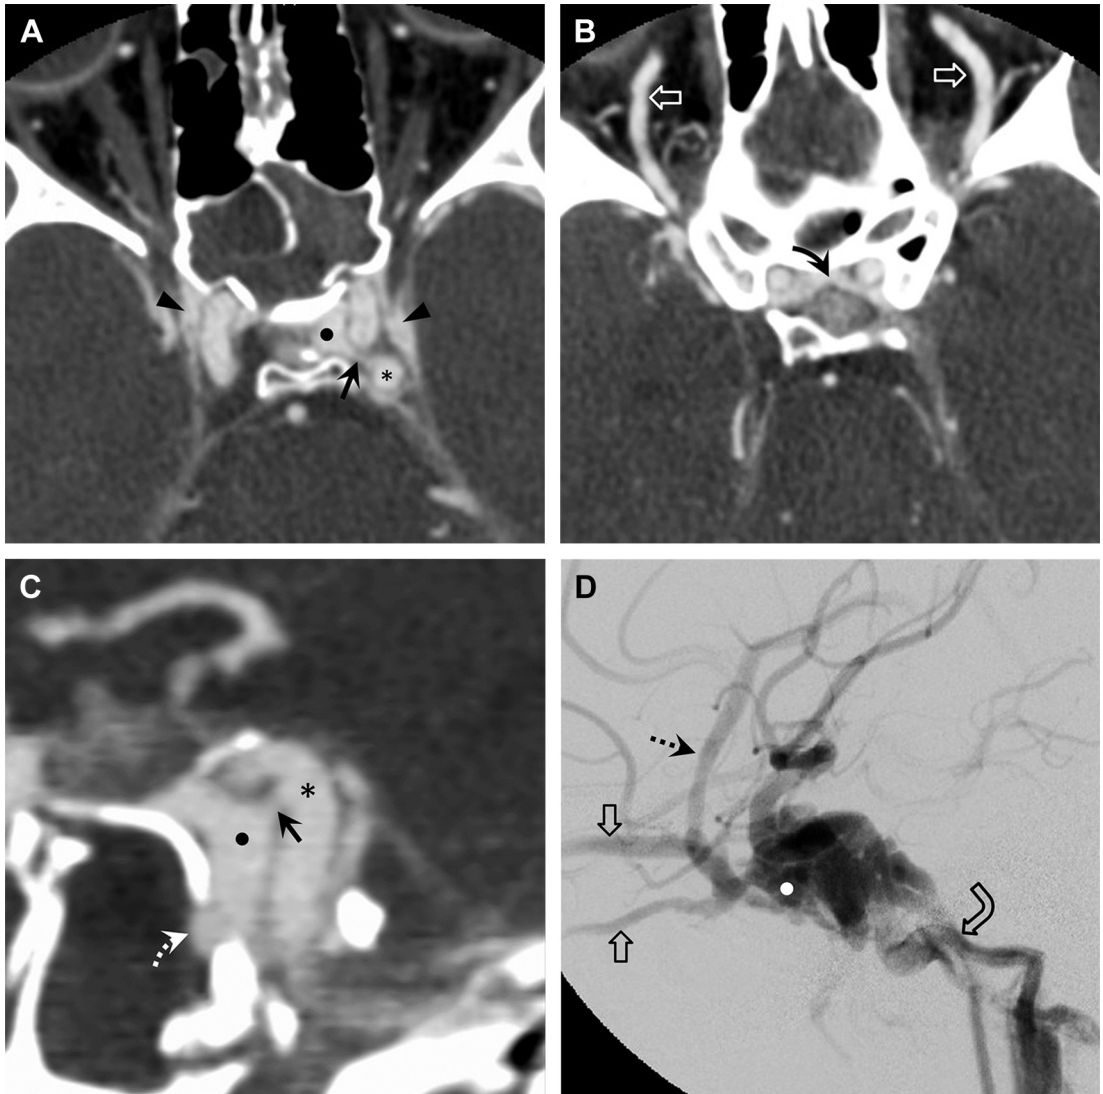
Traumatic carotid-cavernous fistula. (A, B) Axial CTA images demonstrate early filling and dilatation (arterialization) of the cavernous sinuses (arrowhead) due to fistulous connection (arrow) between the left ICA (asterisk) and a large cavernous sinus venous varix (●). There is dilatation of the superior ophthalmic veins (open arrows). Bilateral cavernous sinus involvement is due to a large patent anterior intercavernous vein (curved arrow). (C) Sagittal 2D reconstructed CTA image confirms the fistulous connection (arrow) between the ICA (asterisk) and venous varix (●). The patient is at very high risk of future epistaxis due to extension of the venous varix through a fracture into the sphenoid sinus (curved dashed arrow). (D) Lateral angiogram confirms early entry of contrast into the cavernous sinus (●), ophthalmic veins (open arrows), sphenoparietal sinus (dashed arrow), and inferior petrosal sinus (curved open arrow).
